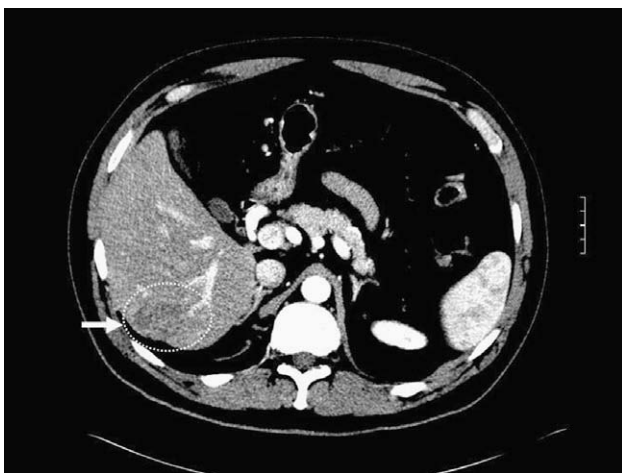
CT Scan showing pre-treatment dominant lesion (3.6×2.8 cm) within segment VI of the liver, suspicious for metastasis (dotted line and arrow).
